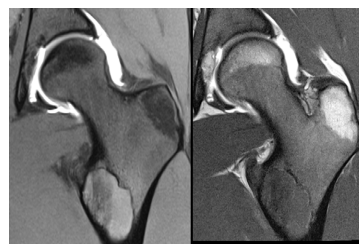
Female, 23 years: Fibrous dysplasia. Arthro-MRI was performed for suspected labral lesion. Localized defect in osteoblastic differentiation and maturation with replacement of normal bone by large fibrous stroma. Coronal proton density weighted image with fat saturation (left) showing higher signal compared to the T1 weighted image (right). Physiologic signal in the femoral head and greater trochanter.
